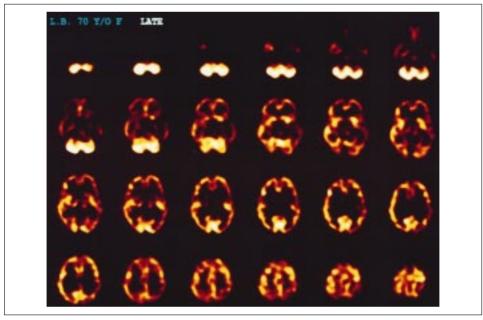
(b) Sequential transverse Tc-99m HMPAO brain SPECT sections (approximately 5 mm thick) from the patient 2 months post-stroke. Marked reduction of regional cerebral blood flow to the thalamus is indicative of bilaretal thalamic infarction.
